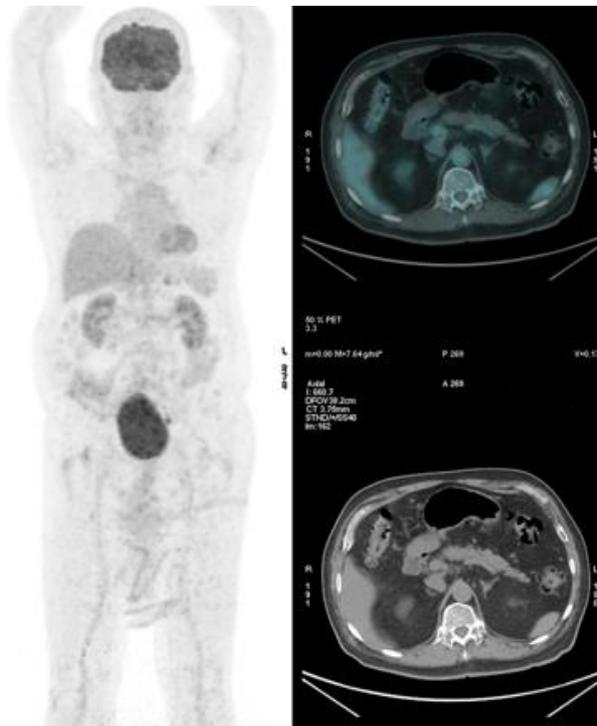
^{18}F -FDG PET/CT.
